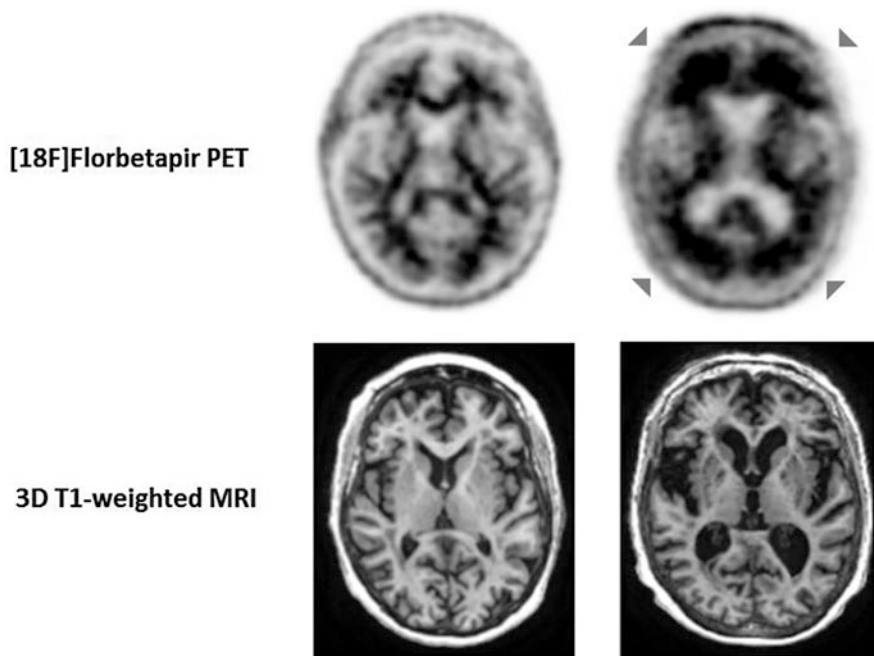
Examples of amyloid PET scans using the radiotracer ^{18}F -florbetapir (*top row*), along with the corresponding 3D T1-weighted MRIs (*bottom row*). The column of images on the right belongs to an 86-year-old female from an AD study cohort, showing a positive amyloid PET scan (cortical regions are *black* representing high uptake in the frontal and temporal regions bilaterally). The column of images on the left belongs to a 77-year-old female from AD/MCI study cohort, with a negative amyloid PET scan (i.e., a nonspecific retention in the white matter, but no uptake in the cortical mantle)
